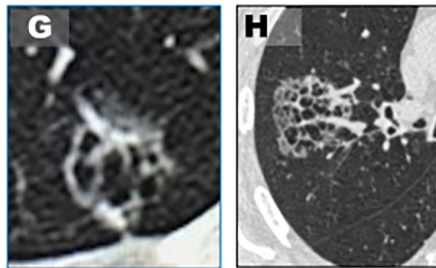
Representative CT images of bullous, pseudocavitary and bubble-like GG LCAL.
